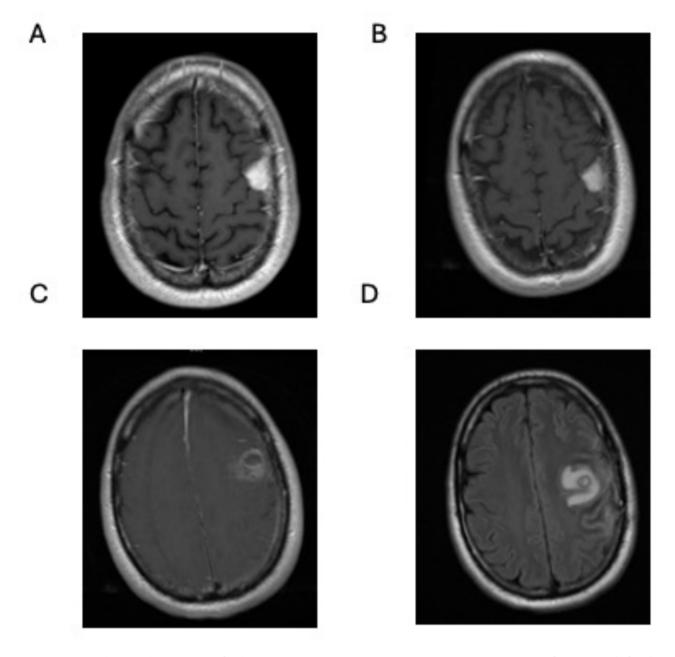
MRI images depicting the progression of melanoma metastasis to a convexity meningioma over time. A: MRI image from one year before the first operation, showing a previously stable meningioma (T1 enhancement). The image reveals a uniform, dural-based enhancing lesion measuring 23.8 × 19.7 × 13.2 mm located at the posterior left frontal convexity. B: MRI image from six months before the first operation, showing a stable meningioma (T1 enhancement). The lesion remains uniform, dural-based, and unchanged in size at the left frontal convexity. C: MRI image obtained nine months after the completion of adjuvant therapy, when the patient presented with progressive headaches followed by word-finding difficulties (T1 enhancement). The image reveals hemorrhage within a left frontal convexity meningioma, which has significantly increased in size since the previous scan. The hemorrhage extends into the adjacent subdural space, resulting in a large left holohemispheric subdural hematoma with a maximal thickness of up to 10 mm. Additionally, thin subdural hematomas are observed along the left anterior falx. D: MRI image obtained one month after the first surgery, when the patient exhibited progressive neurological symptoms (FLAIR). The image shows an extra-axial fluid collection within the left frontal resection cavity
